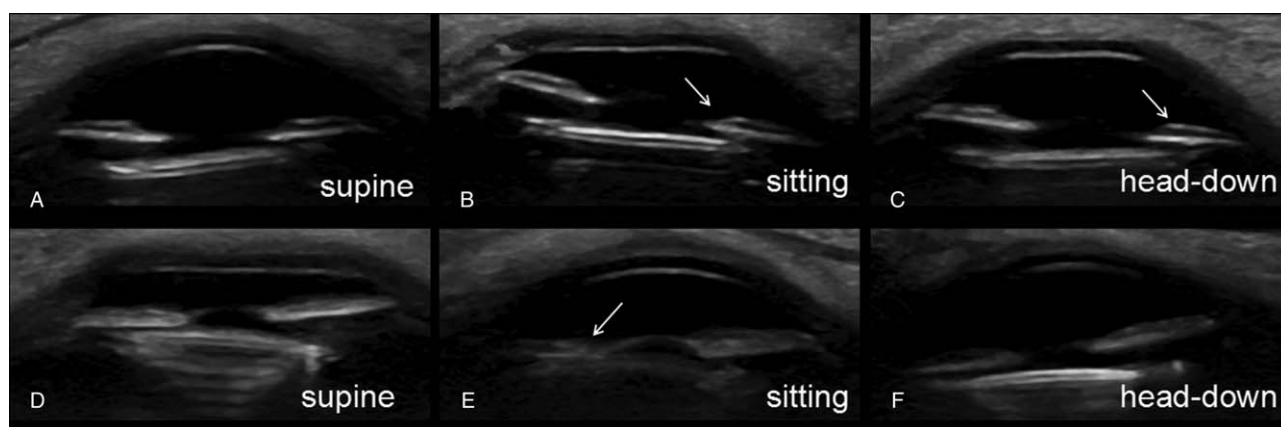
B-ultrasonography images. B-ultrasonography of the right eye (A–C) and left eye (D–F) in various head positions: supine (A, D), sitting (B, E), and head-down (C, F). In A, D, and F, IOL and haptics were not in contact with the iris. In B, C, and E, chafing between IOL and iris was identified (as the arrows show). IOL: Intraocular Lens.
